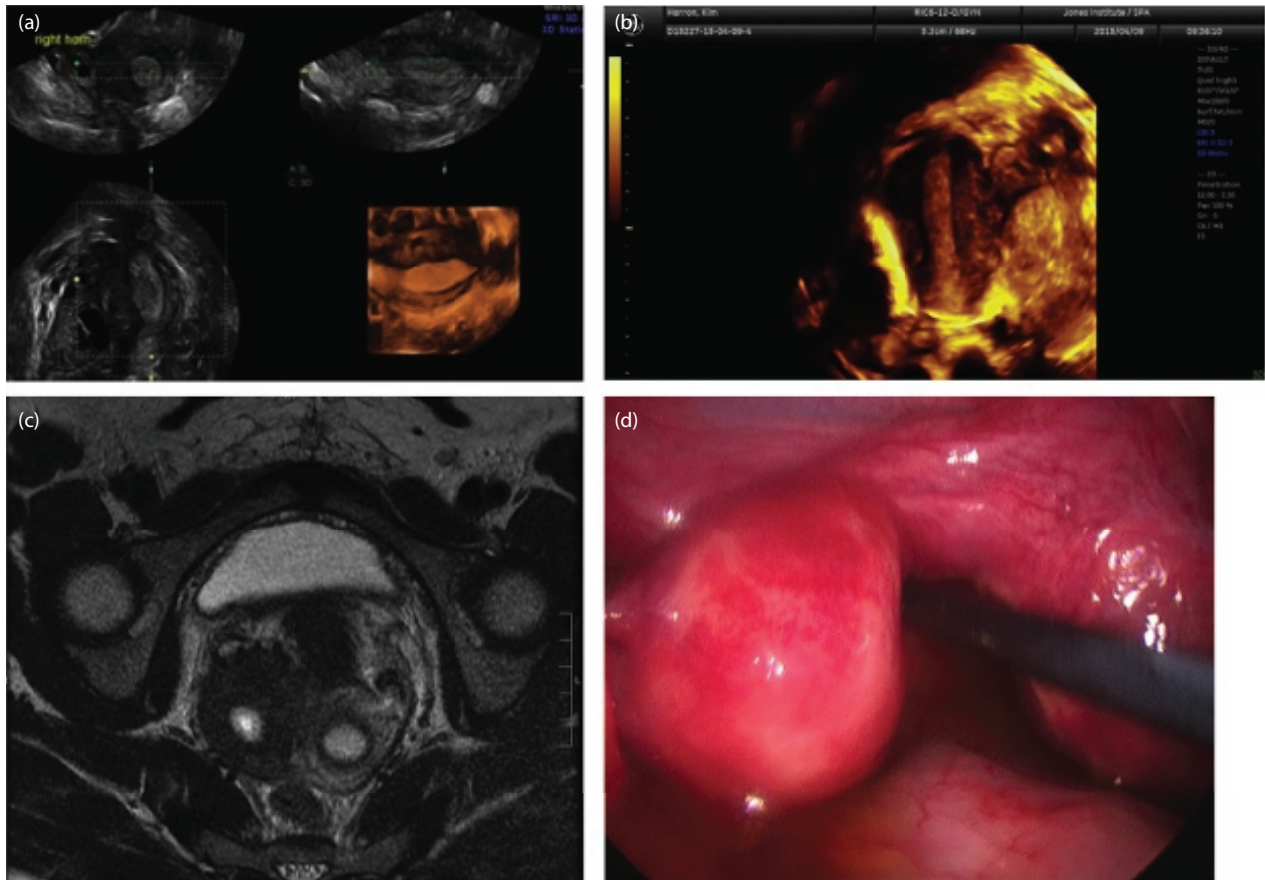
(a) Three-dimensional (3D) manipulation of unicornuate uterus. (b) Unicornuate uterus non-communicating horn in 3D. (c) Magnetic resonance imaging of unicornuate uterus with non-communicating horn. (d) Laparoscopy of unicornuate uterus with horn.
